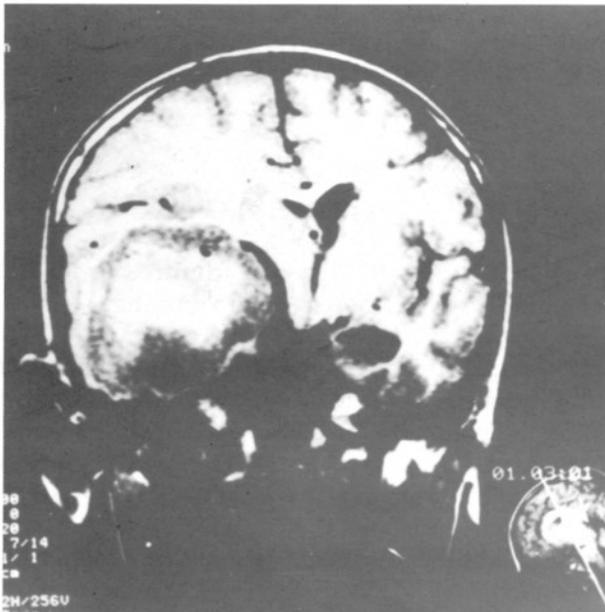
T1-weighted coronal MRI image showing a right temporal mass with an haemorrhagic hyperintense center and causing a midline shift.
